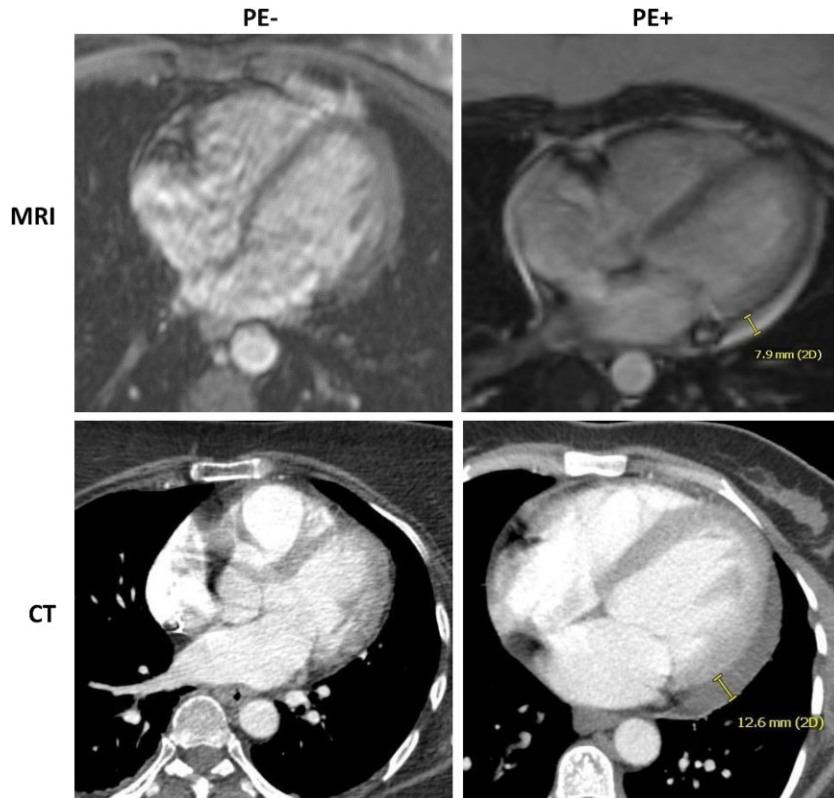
Representative axial scans of the heart showing normal pericardium (left) and pericardial effusion (right). MRI: T2-weighted sequence.
